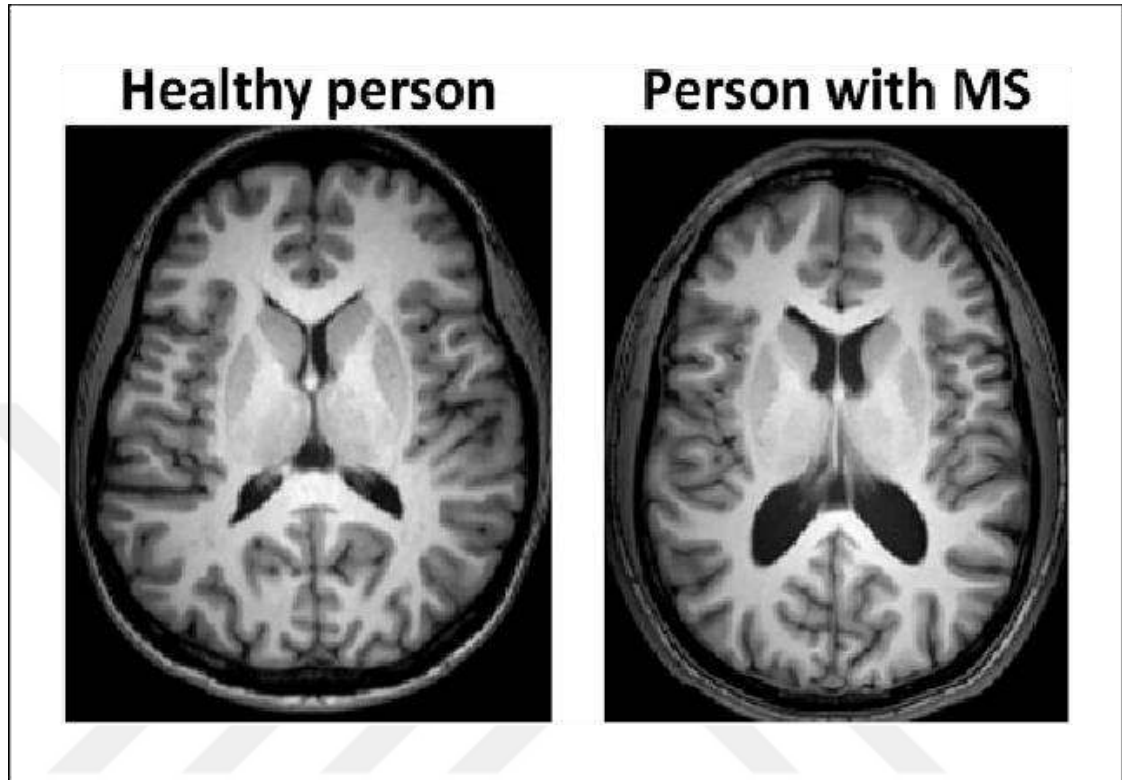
Brain MRI images of healthy individuals and MS patients (Polman *et al.* 2011)
